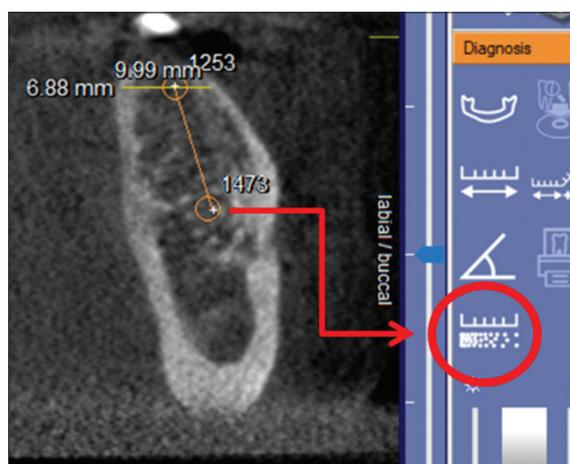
Gray scale values shown by the tool marked as red circle, in the Galileos viewer, cone beam computed tomography software
